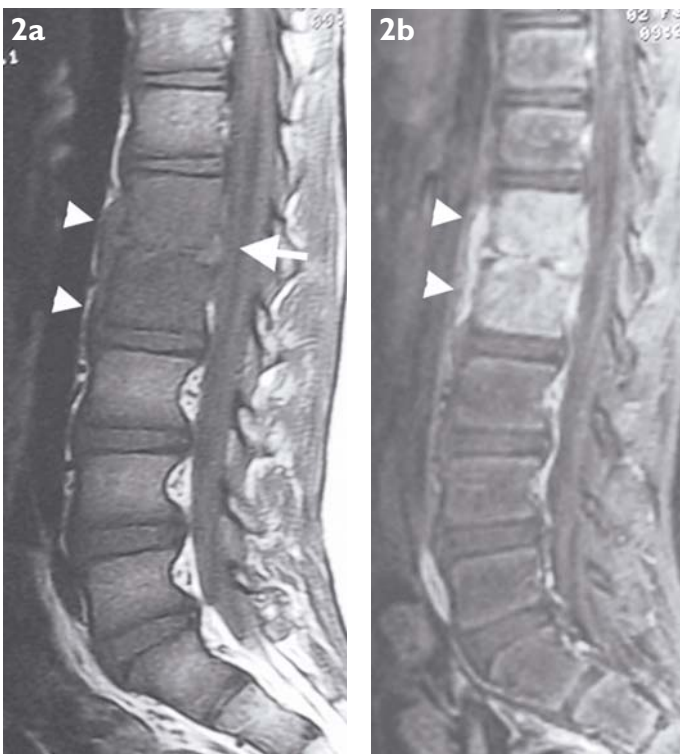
Subligamentous spread of TB in a 10-year-old boy. a) Sagittal T1-W MR image shows narrowing of L1/2 intervertebral disc space (arrow). The L1 and L2 vertebral bodies are hypointense due to bone marrow inflammation and oedema. Subligamentous soft tissue spread is seen (arrowheads). b) Enhanced fat-suppressed sagittal T1-W MR image shows enhancement of the L1 and L2 vertebral bodies, L1/2 disc and subligamentous inflammatory tissue (arrowheads).
